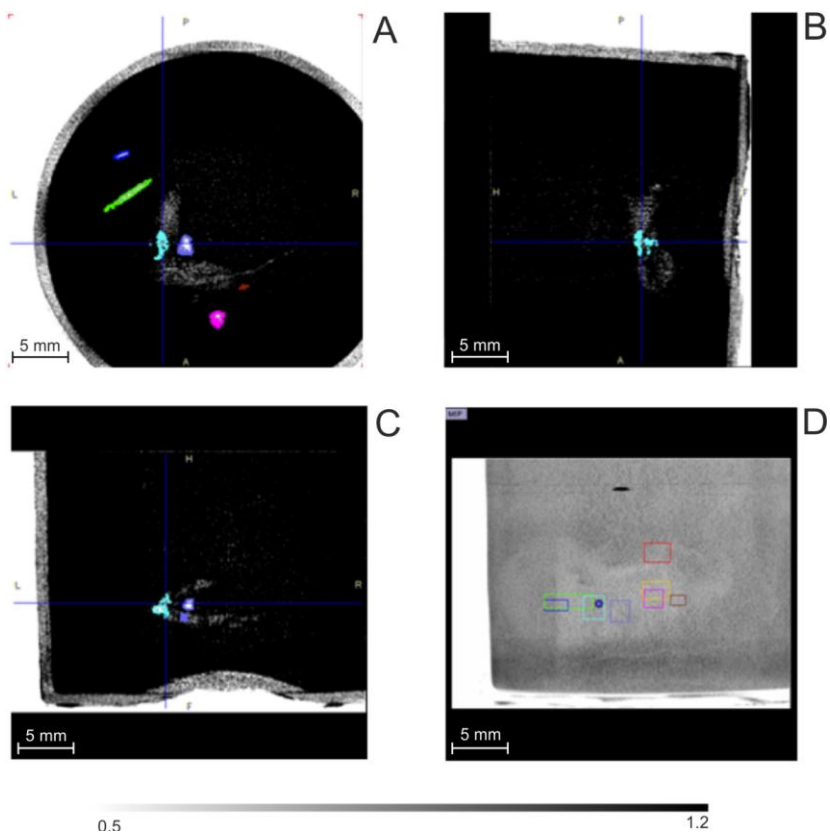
CT image of the three orthogonal views of the kidney A, loaded to 55% v/v Me_2SO , in which has been inserted eight drops of water and then cooled to -196°C . The image was taken at -140°C and it uses the gray scale
